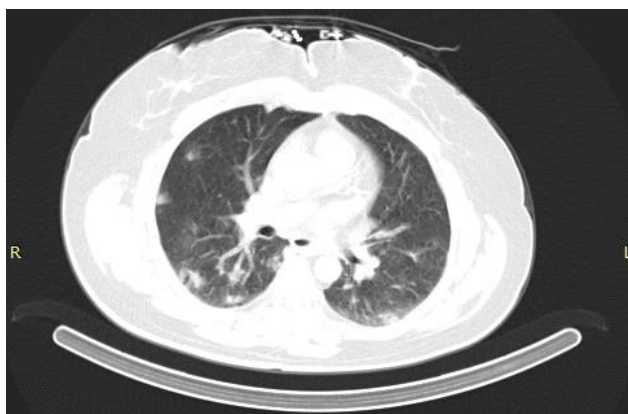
CT images in lung window showed multifocal, bilateral and peripheral ground glass opacities in lungs.
